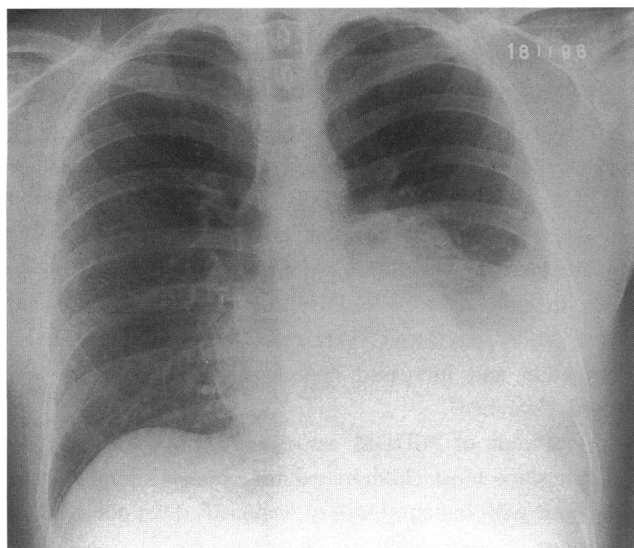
Chest radiograph at initial presentation
